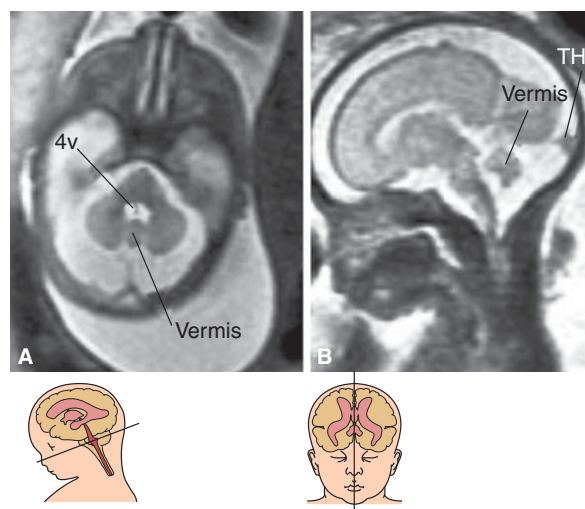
MRI of Blake's pouch cyst. When compared with the sonograms in the previous figures that were obtained from the same fetus, the most important contribution of MRI is the clear demonstration of the torcular herophili (TH) that is normally inserted. (Reproduced, with permission, from *Atlas of Obstetric Ultrasound*, 2009. The Global Library of Women's Medicine. www.glowm.com.)
